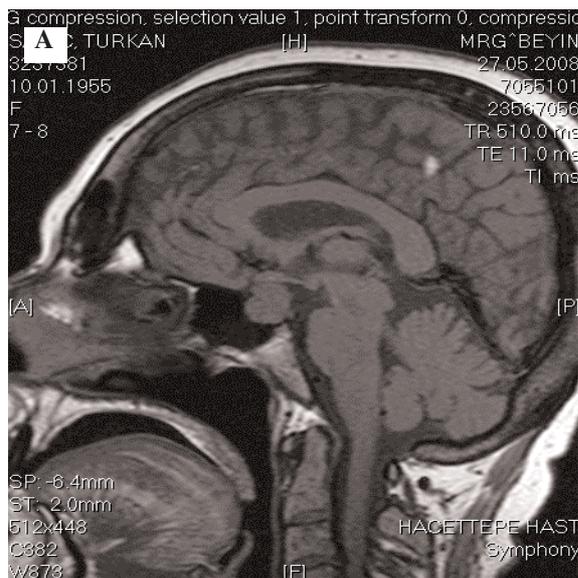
Sagittal MRI showing pituitary mass
